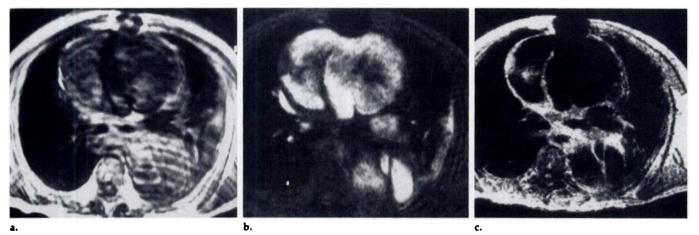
MR images obtained in a 73-year-old male patient with complex triple-barreled type A thoracic aortic dissection. (a) SE image with parallel presaturation (400/15, 256×192 matrix, 36×36 -cm field of view, 5-mm section thickness) obtained in approximately 4 minutes is difficult to interpret due to persistent intravascular signal. Signal void from sternal wires is present anteriorly. (b) Axial breath-hold flow-compensated GRE image (25/8, 30° flip angle, 5-mm section thickness, 256×256 matrix, and 40×40 -cm field of view) shows mixed signal intensity within ascending aorta and in one of two false lumina of the descending aorta due to extremely low flow velocity. (c) More precise evaluation is obtained with a breath-hold axial selective preinversion turboFISP image (256×256 matrix, 44×44 -cm field of view, 1,800-msec TR, and 475-msec TI). Only a small persistent focus of signal intensity is seen within the lumen of the ascending aorta.
